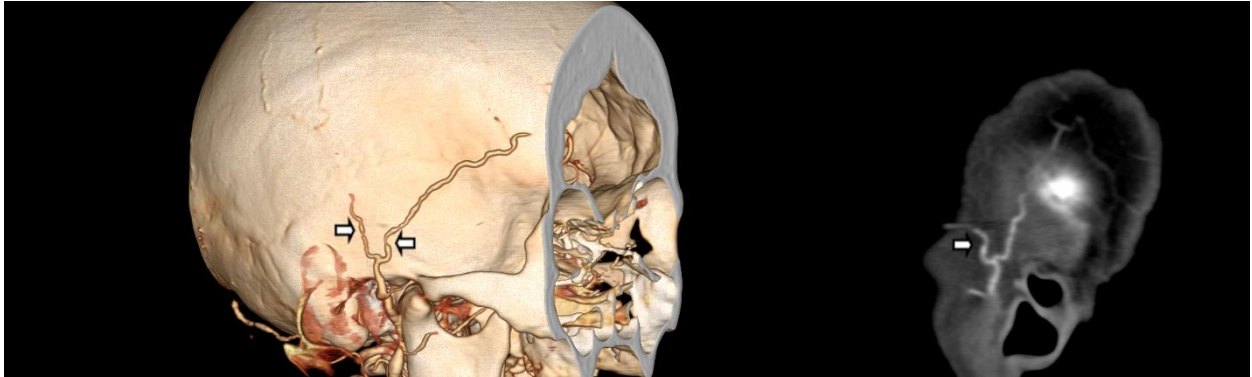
Volume rendered 3D image from a CTA of the head on the left demonstrates multiple areas of narrowing along the temporal artery in a patient with temporal arteritis (short arrows). A sagittal reconstructed Thin MPR image on the right also demonstrates areas of narrowing in the right temporal artery (short arrow).
